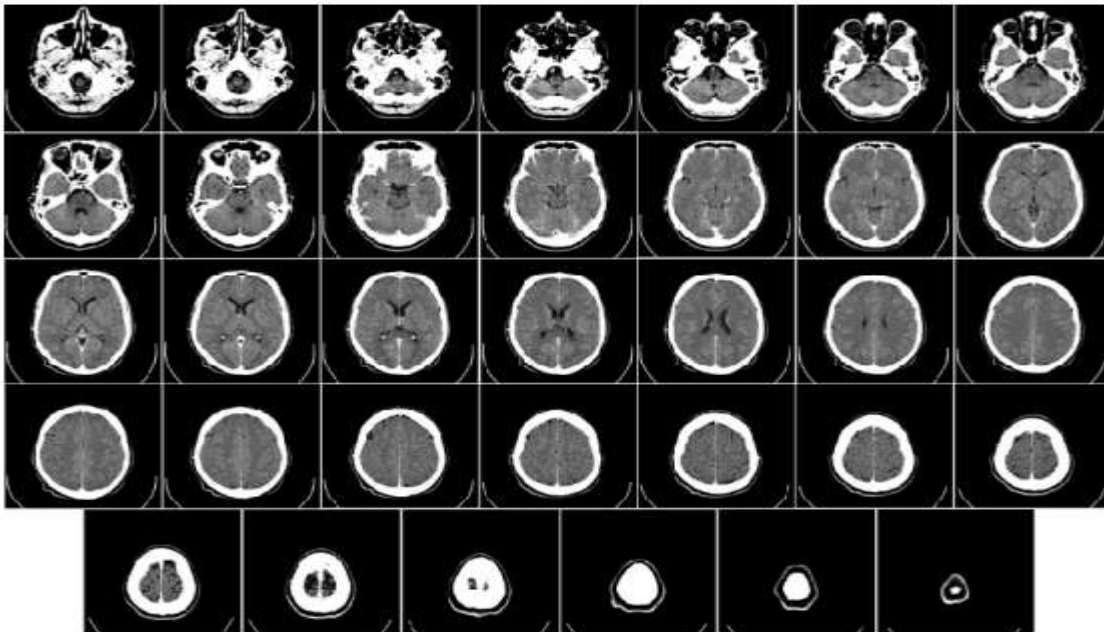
CT DICOM images of human brain, from base of the skull to top
